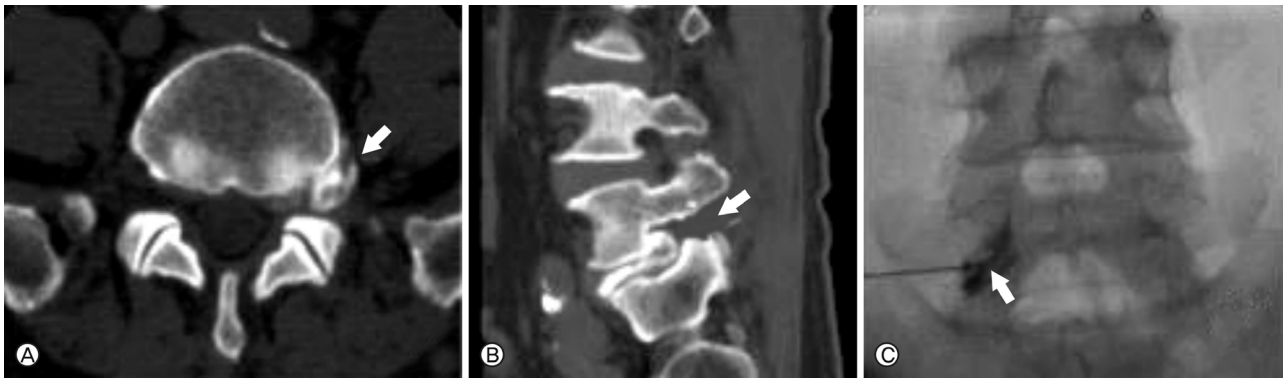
Left L5-S1 far lateral lumbar disc herniation was shown in axial image (A) and sagittal image (B) on computed tomographic discography. Left L5 Selective nerve root block image (C).
